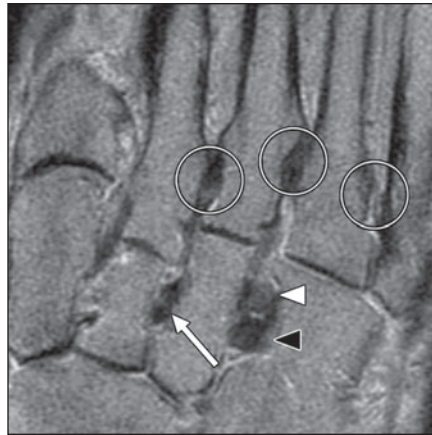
Tarsal and metatarsal interosseous ligaments. Transverse oblique MR image after injection of intraarticular gadolinium solution shows intermetatarsal interosseous ligaments (circles), interosseous intercuneiform ligament between C2 and C3 (arrow) and two bands of interosseous ligament between C3 and cuboid (superior band—white arrowhead, inferior band—black arrowhead).
